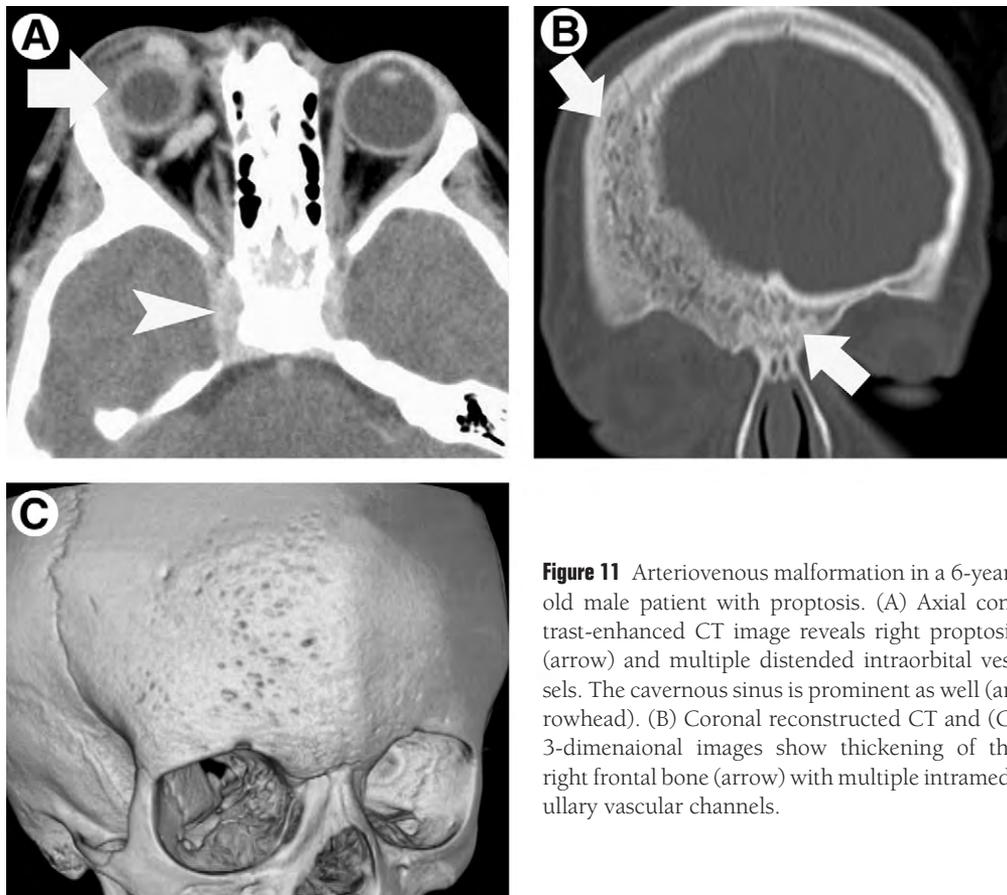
Arteriovenous malformation in a 6-year-old male patient with proptosis. (A) Axial contrast-enhanced CT image reveals right proptosis (arrow) and multiple distended intraorbital vessels. The cavernous sinus is prominent as well (arrowhead). (B) Coronal reconstructed CT and (C) 3-dimensional images show thickening of the right frontal bone (arrow) with multiple intramedullary vascular channels.
